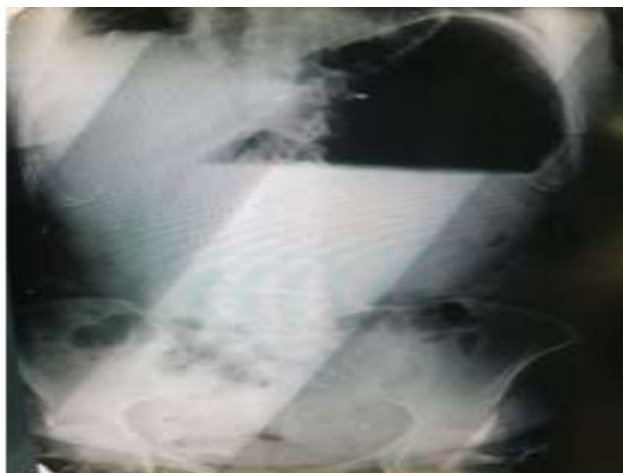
Simple abdominal X-ray, showing large gastric distention.
